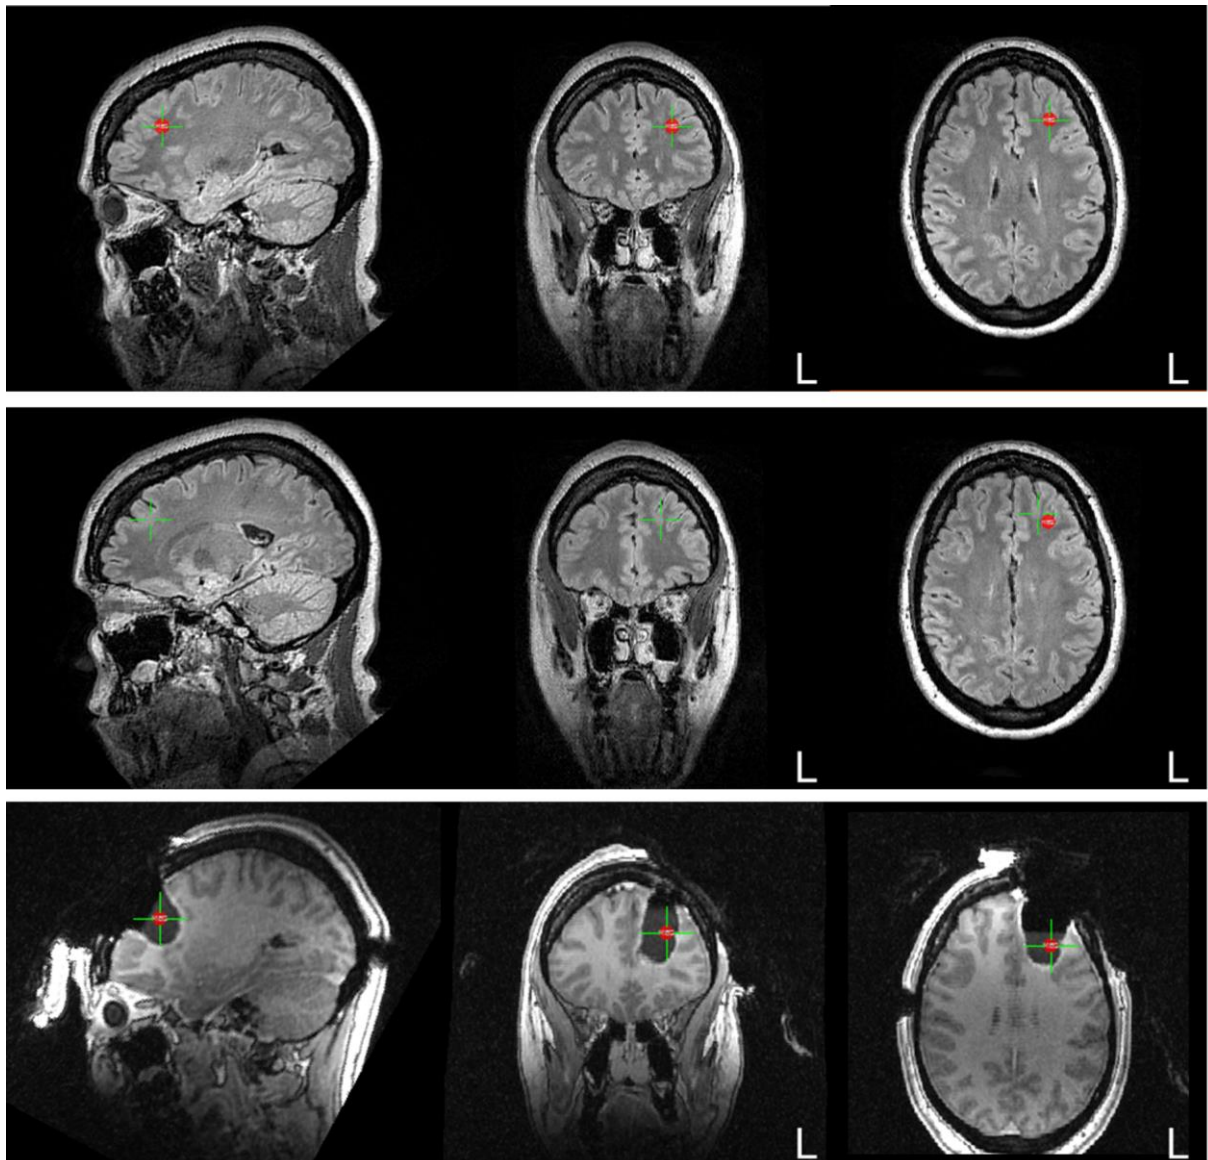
Patient example. MEG localized (average of 33 spikes) to the left frontal lobe (top row), slightly lateral to the FCD IIb (middle row, intraoperative MRI immediately after resection). Resection included the lesion, as well as the MEG result. Postsurgical outcome was Engel 1a, one year follow-up.
